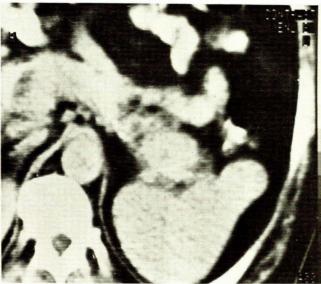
CT scan with contrast. The insulinoma, anteromedial to the spleen, is in the tail of the pancreas.
